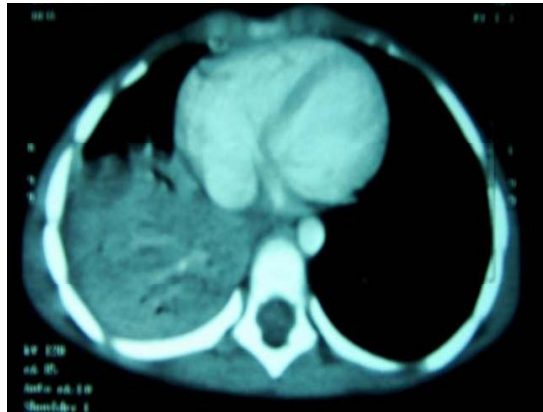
Combined right middle and lower lobes collapse with CT arteriogram sign
